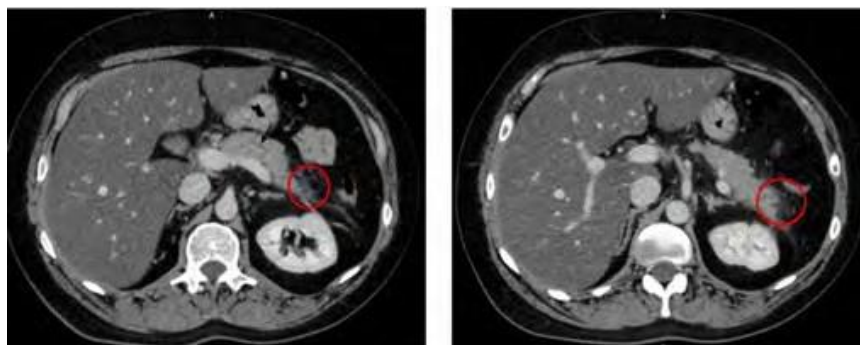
Axial CT (venous time), highlighting a normal-sized pancreas with disreputable edematous appearance, visible Wirsung duct with normal calibre (black arrow), associating peripancreatic fat infiltration (red circles), predominantly at the corporeal and caudal level. There is no evidence of fluid collections or pancreatic necrosis on the sections at the time of the scan. mCTSI score = 2 (acute mild pancreatitis).
